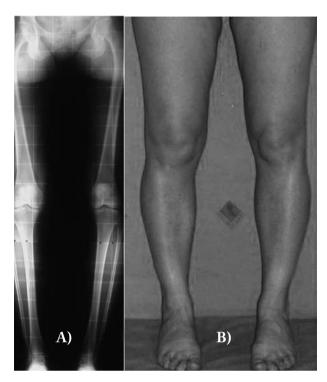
Bilateral genu varum in a patient of 40 years of age; preoperative long weight bearing lower limbs radiographs (A) and clinical image (B)
